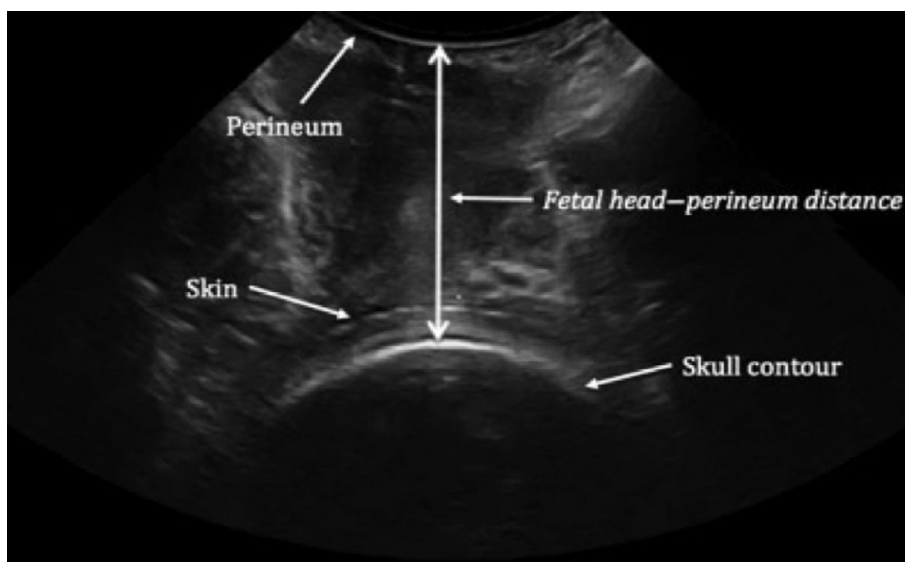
Ultrasound image showing how the fetal head–perineum distance (60 mm) can be measured as the shortest distance between the outer bony limit of the fetal skull and the perineum in a transverse view (with permission from Torkildsen *et al.*⁴¹).
